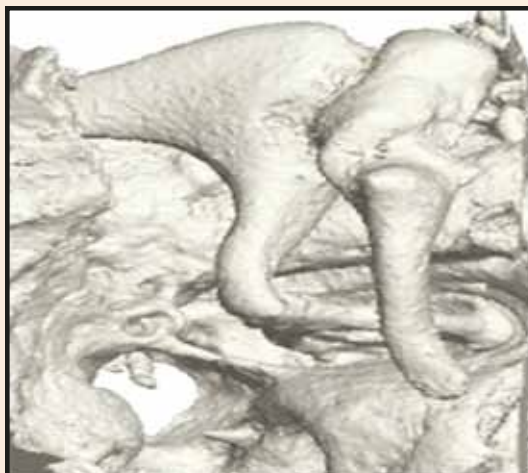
Reformatted high-resolution CT scan showing the ossicles of the middle ear.
